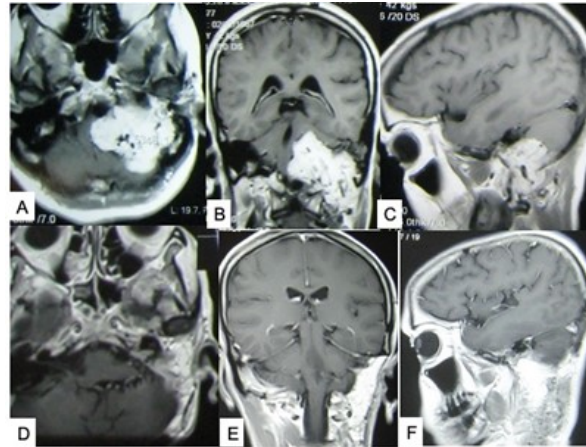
Contrast MRI of head. (A–C) Show left-sided large glomus jugulare; (D–F) show excision of the tumour. Source: Figure by authors.
